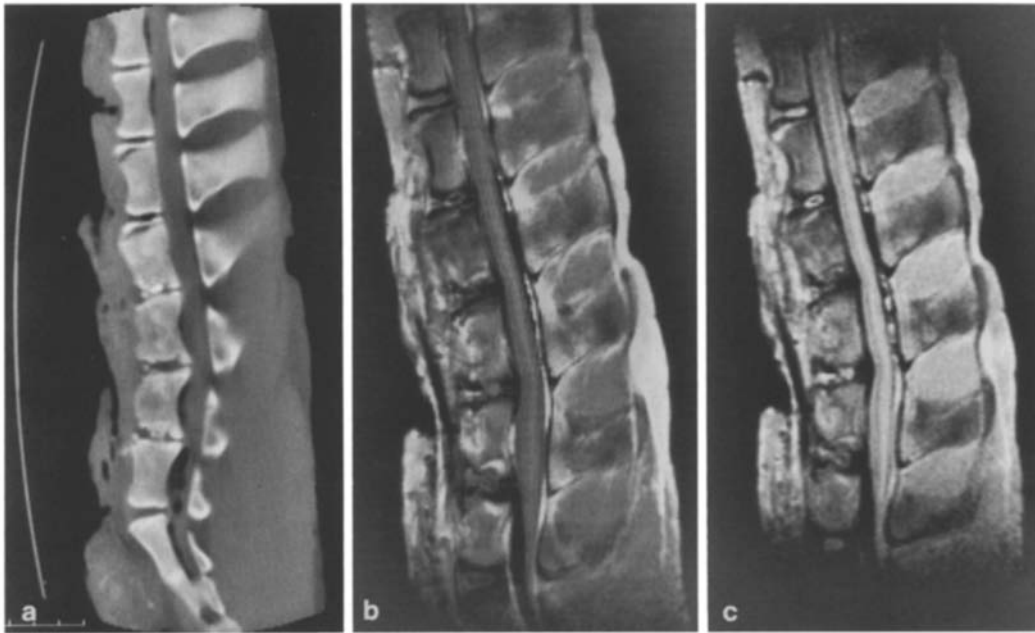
a Sagittal CT cut of the lumbar spine block of minipig A at 24 weeks. In addition to the changes visible in the plain film, the L3 cranial epiphyseolysis is also in the field. Note the reactive vertebral body sclerotic changes, most clearly visible at the cranial part of the L4 vertebral body, and the intraspinal air surrounding the thecal sac. b Sagittal MR T1WI (SE 500/20 ms, the L2 vertebra is at the top end) of minipig A at 24 weeks, demonstrating clearly increased signal intensity of the operated L4–7 vertebral bodies and also at the caudal end of the L3 vertebral body, reflecting reactive bone marrow changes (fatty conversion). The cranial epiphyseolyses on L3 and L4 are visible as high signal intensity bands. The abundant anterior longitudinal ligamentous thickening and calcification are clearly visualized. c Sagittal MR proton density image (SE 2500/22 ms, the L2 vertebra is at the top end) with a myelographic effect. The thecal sac is compromised anteriorly at the L5–7 IVDSs by the low-signal posterior longitudinal ligament and osteophytes. The thecal sac looks slightly flabby, as the normal physiological pressure of the cerebrospinal fluid is absent
